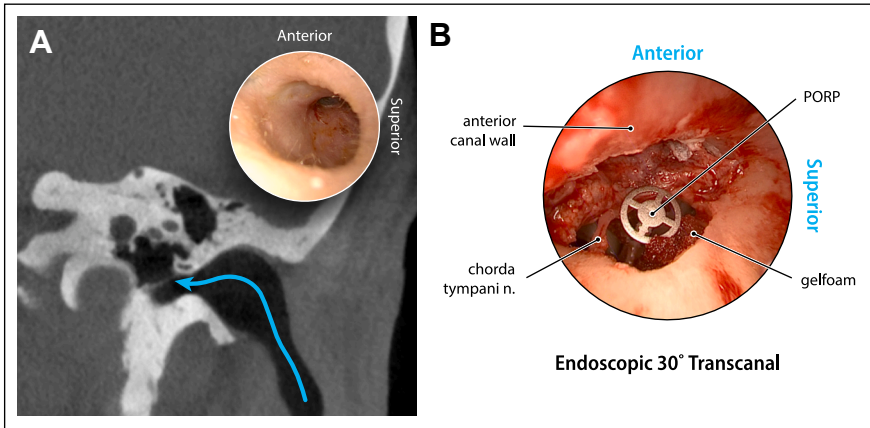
Tortuous ear canals on CT. (A) Coronal CT temporal bone demonstrating the tortuous ear canal of a patient with Turner syndrome and the endoscopic 0° view of the ear canal as an inset. (B) Endoscopic 30° view of prosthesis placement via transcanal endoscopic approach.
